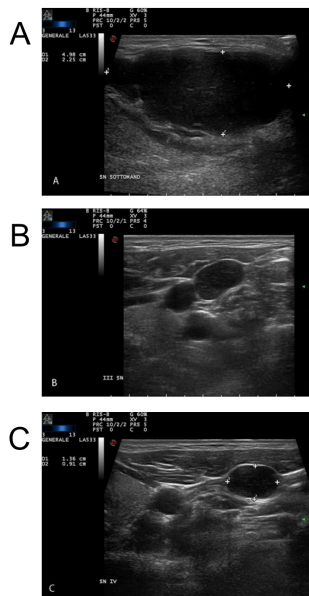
Ultrasound images of the nodules. (A) Ultrasound examination of the left submandibular area showing a major hypoechoic mass with regular margins and light internal lobulations. (B) Normal appearing lymph nodes between Level III and (C) Level IV of the neck.
